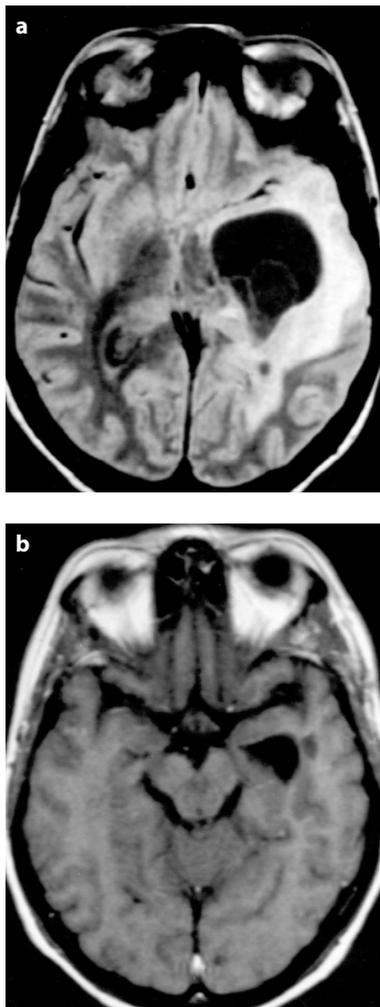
a Axial FLAIR MRI demonstrating blockage of the temporal horn by cysts. b Axial T1-weighted MRI after endoscopic cyst removal
